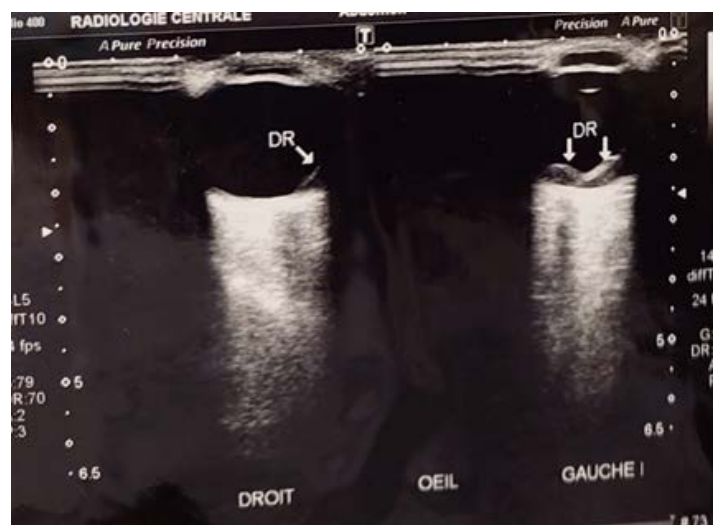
B-mode ocular ultrasound showing bilateral retinal detachment.
